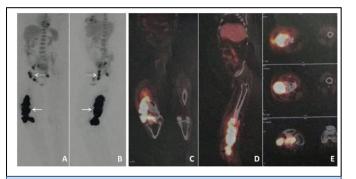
Antero-posterior (A) and Lateral (B) PET images demonstrating differential FDG uptake in lower end of femur and adjacent soft tissue (white arrow). Differential FDG uptake is also seen in right iliac and inguinal nodes (dashed white arrow). Antero-posterior (C), Lateral (D) and Axial (E) Fused PET-CT images demonstrating intense hypermetabolism in lower end of femur and adjacent soft tissue.
